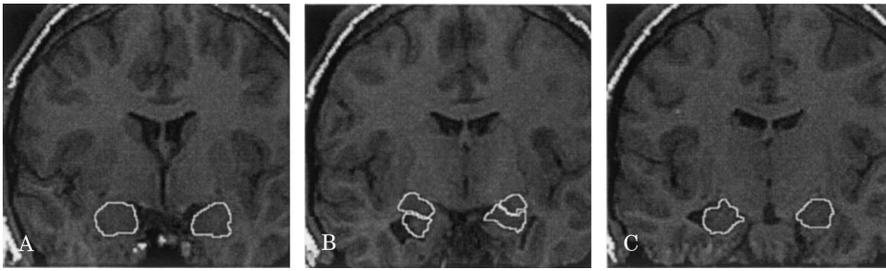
Representative T1-weighted coronal MRI slices demonstrate boundaries of amygdala (A and superior structures in B) and hippocampus (C and inferior structures in B) used to delineate volumes.
